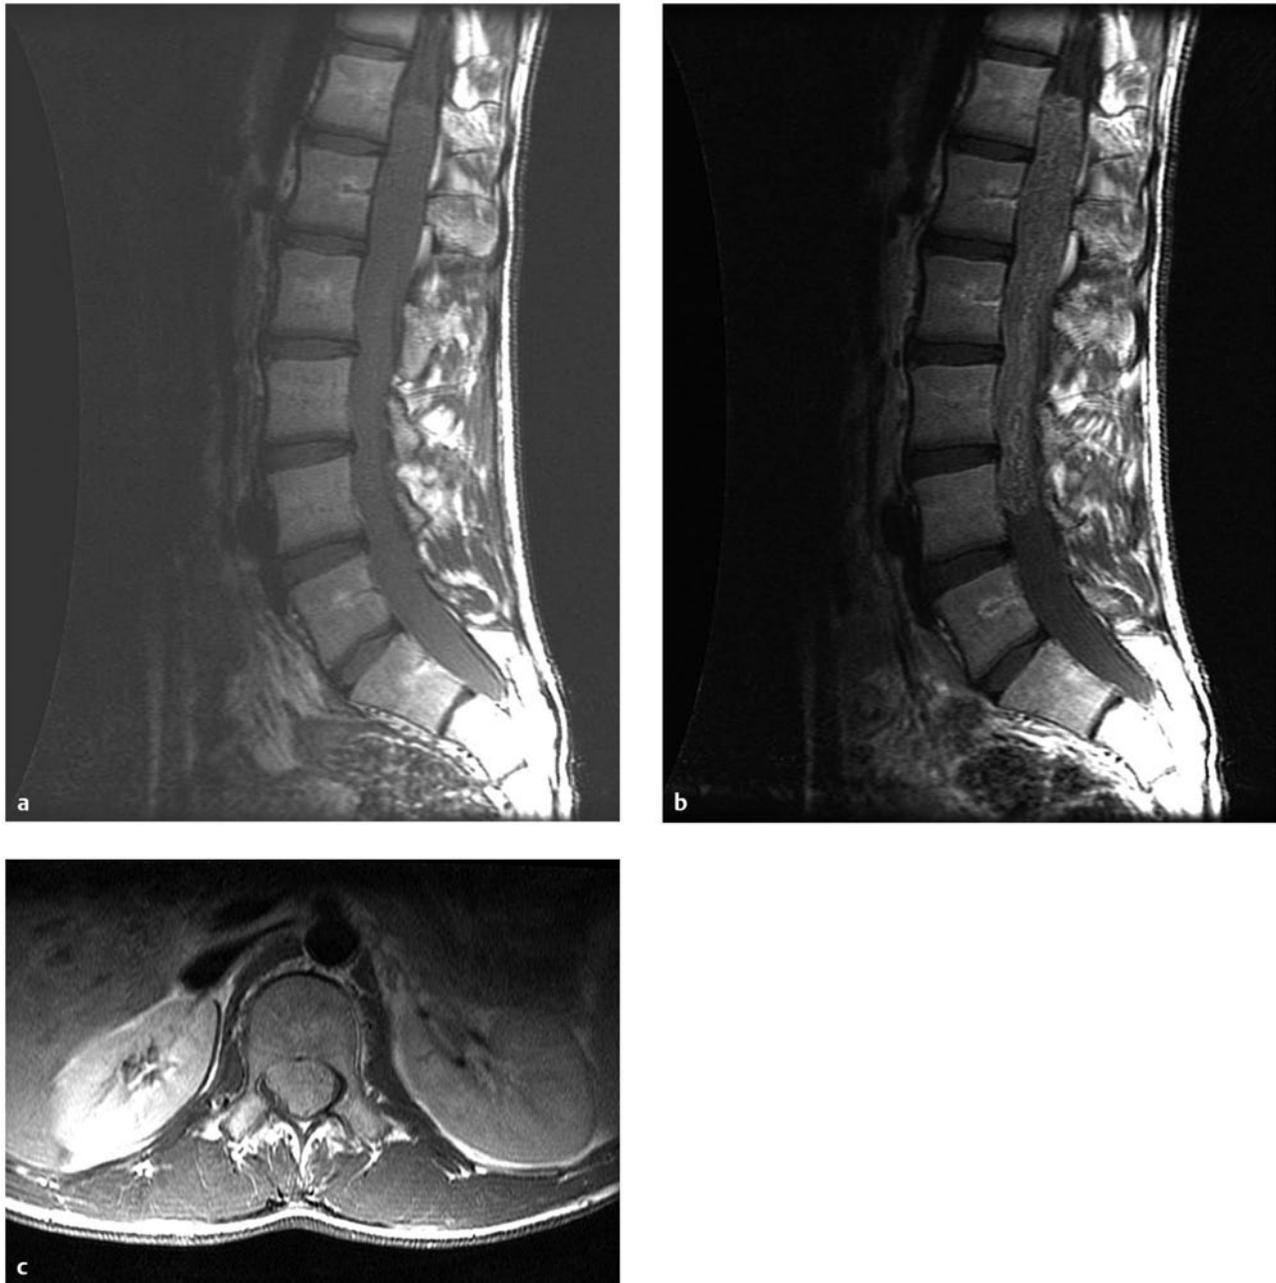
Myxopapillary ependymoma in a child with back pain. (a) Sagittal T1-weighted magnetic resonance (MR) image without contrast shows an intradural tumor filling the thecal sac in the low thoracic and lumbar spine. (b) Added intravenous contrast better defines the tumor and shows that it extends from T12 to L4. (c) Axial image shows the tumor filling the thecal sac, displacing the nerve roots to the periphery of the sac.
